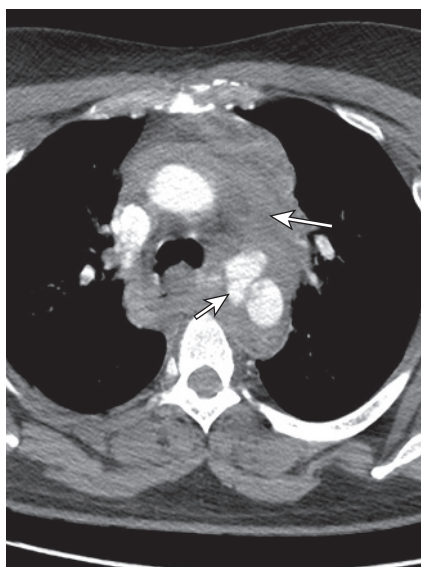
Axial post-contrast computed tomography following aortic transection with a mediastinal haematoma (*long white arrow*) and active contrast extravasation from the thoracic aorta (*short white arrow*).
